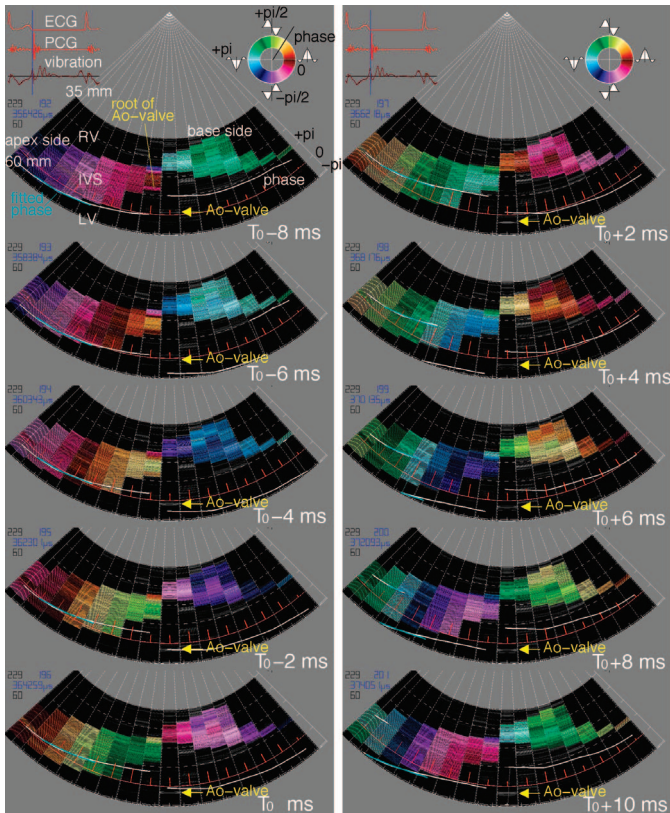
Spatial distributions of color-coded phase values for 60-Hz component of the wavelets in Fig. 2. The spatial distributions are shown consecutively from $T_0 - 8$ ms to $T_0 + 10$ ms around the time of AVC (T_0). White lines show the instantaneous phase $\theta(x; t)$ used in (1) of the pulsive wave at the LV surface of the IVS, and blue lines show the estimated phase $\hat{\theta}(x; t)$ in (1). These phase values were interpolated between the adjacent ultrasonic beams and are shown here. The supplemental animation [1] shows the distributions of the phase values for 60-Hz component in the parasternal view for subject A. Each figure around the time of AVC (T_0) is shown here.
